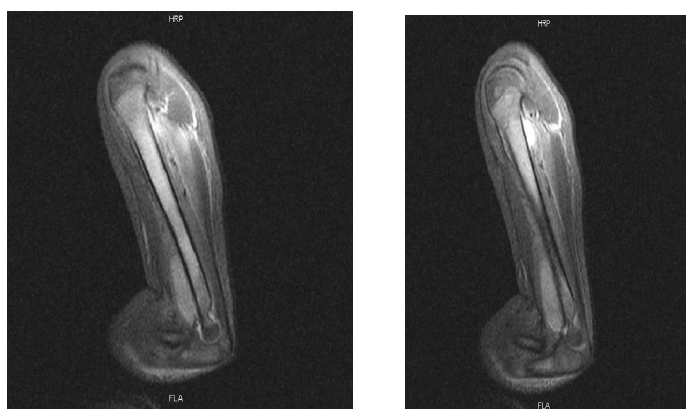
Magnetic resonance imaging of the left shoulder and humerus performed 7 days after onset of illness revealed hyperintense signal in the marrow with a small pocket pus elevating the periosteum and soft tissue swelling of the left humerus suggesting osteomyelitis.
